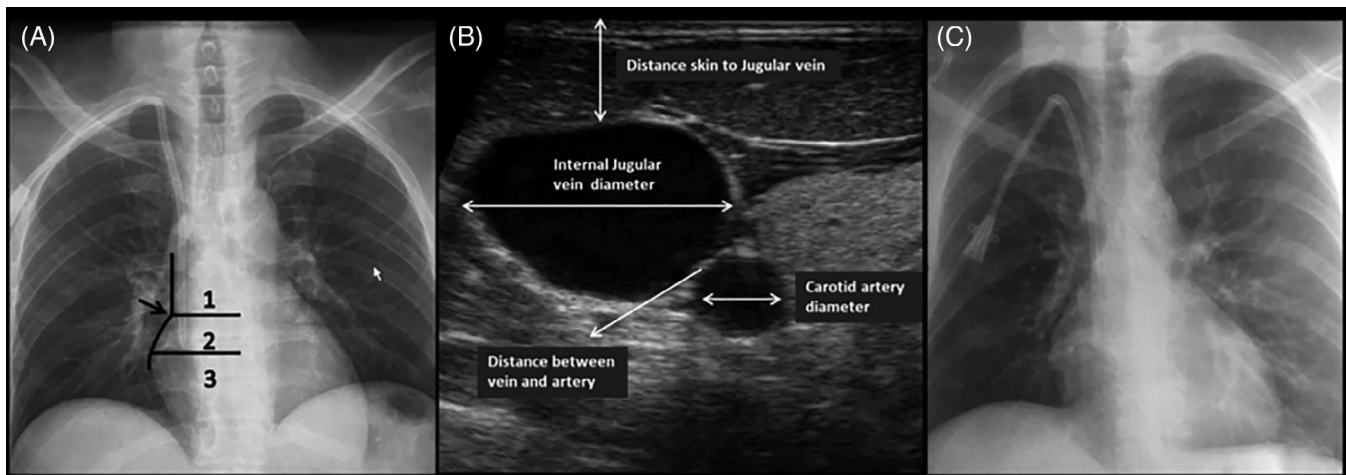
(A) x-ray image of the chest in the supine position demonstrates zones used to categorize catheter tip location into (1) superior vena cava, (2) cavo-atrial junction or (3) mid- to deep right atrium. The concave angulation formed by the border of the right atrium convexity and the right mediastinal border defined the border between zones 1 and 2 (arrow). (B) Ultrasound short-axis technique of the internal Jugular vein, carotid artery, distance between vein and artery and distance between skin and internal Jugular vein. (C) incorrect catheter TOP position (kinking)
